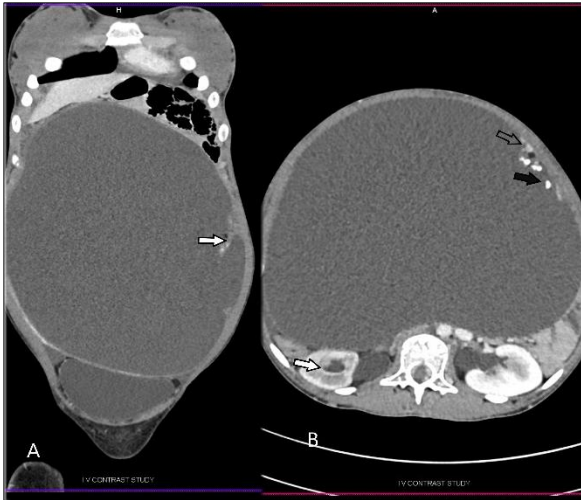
A) Coronal contrast-enhanced CT image shows a large thin-walled abdominopelvic cystic mass with a thick septae along its left lateral wall (white arrow). B) Axial contrast-enhanced CT image shows a large thin-walled cystic mass with few eccentric calcific foci (black arrow) and a focal fatty attenuation (hollow arrow). There is mild right hydronephrosis (white arrow).
